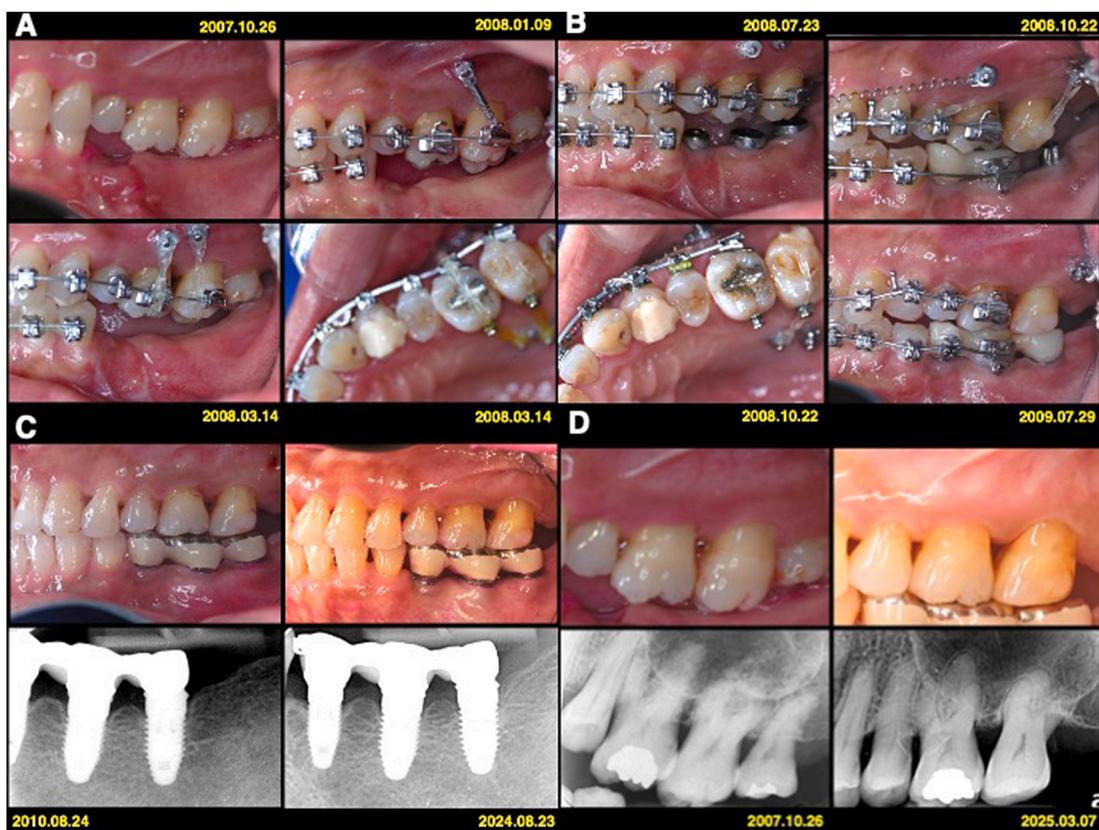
Clinical photographs and radiographs of the patient. (A) A 47-year-old female patient presented with missing posterior teeth 35, 36, and 37 and opposing extruded molars, rendering inadequate interocclusal space for implant restoration. To create enough space for the implant replacement of the mandibular molars, the treatment plan involved extraction of the left maxillary third molar, followed by the intrusion of the overerupted left maxillary first and second molars using mini-screw anchorage. The miniscrews (2 mm in diameter, 10 mm long, A1 Anchor Screw System, BioRay Biotech, Taichung, Taiwan) were inserted into the left maxillary buccal alveolar bone: one in the tuberosity and the other above the roots of the first molar. The palatal anchorage was supplied by two miniscrews in the left paramedian area of the palate. Immediately after screw placement, about 150–200 g of intrusive forces were delivered with power chain from the miniscrew heads on both sides to bonded buttons on the overerupted molars. The power chain was replaced monthly. (B) After nine months of intrusion, the maxillary molars were in the acceptable position and a temporary bridge (implants 35 and 36) was delivered to provide function. (C) Clinical and radiographic evaluations at the 14-year follow-up revealed a healthy periodontal and peri-implant tissues with minimal tissue recession and marginal bone loss. (D) After 17-year follow-up, a 2.1 mm M intrusion was achieved at the tooth 26, and 3.2 mm at the tooth 27. The root resorption of 0.58 mm was observed at the tooth 26, while 0.28 mm was noted at the tooth 27.
